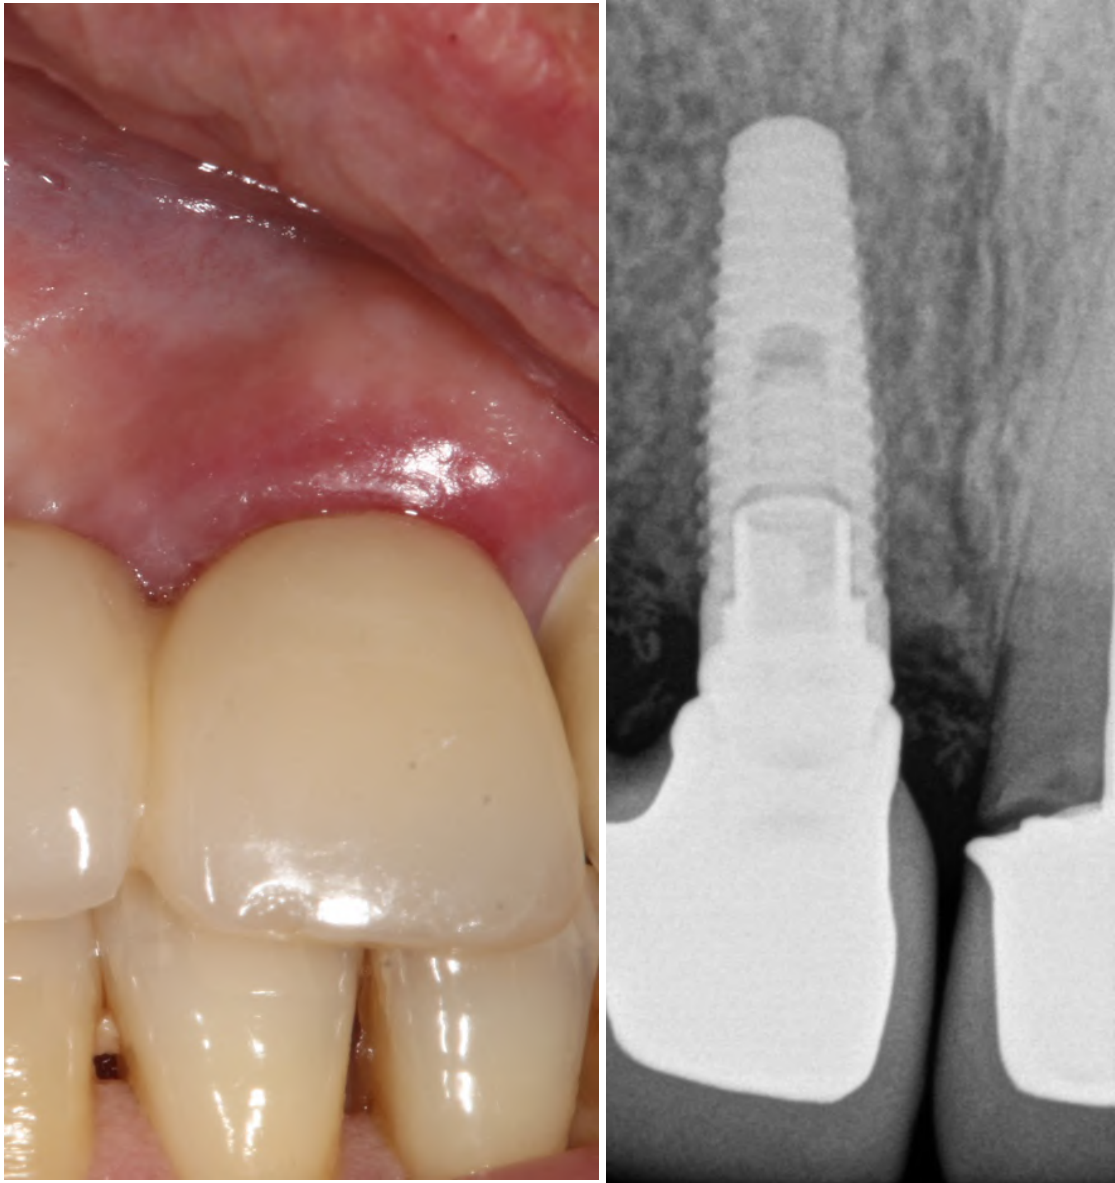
Clinical and radiographic appearance of peri-implant mucositis. Original picture.
